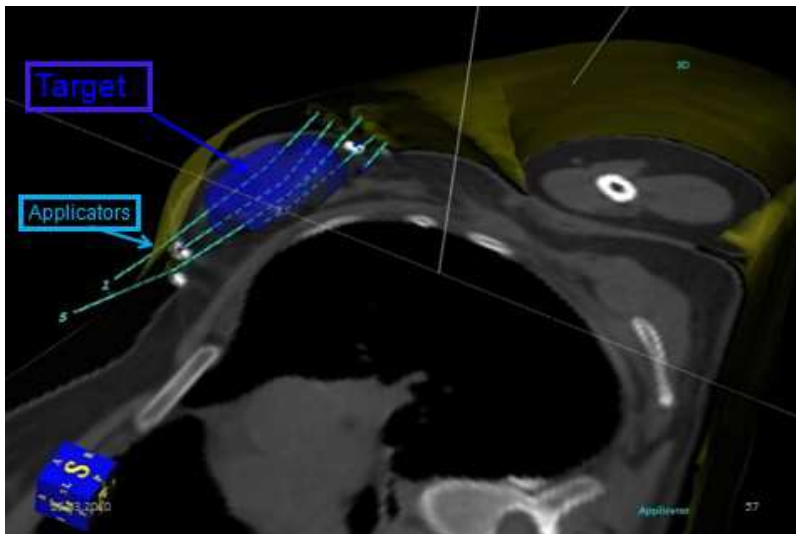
Breast cancer – CT-based 3D image of Oncentra Planning System® (Nucletron), with target and applicators.
